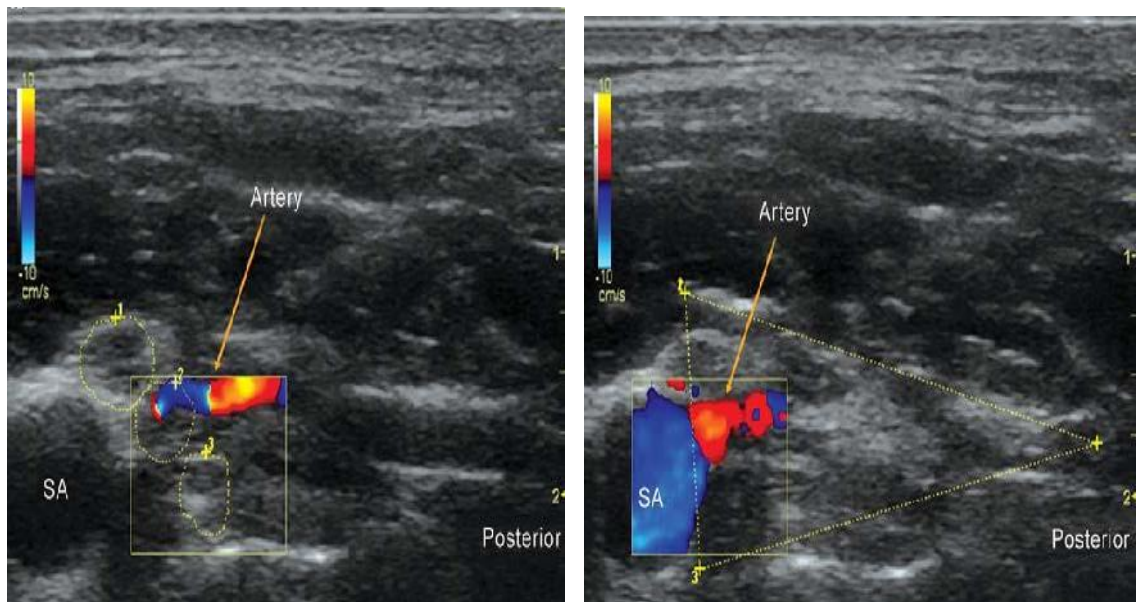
Showing a branch of subclavian artery coursing through brachial plexus on colour doppler. SA, subclavian artery
